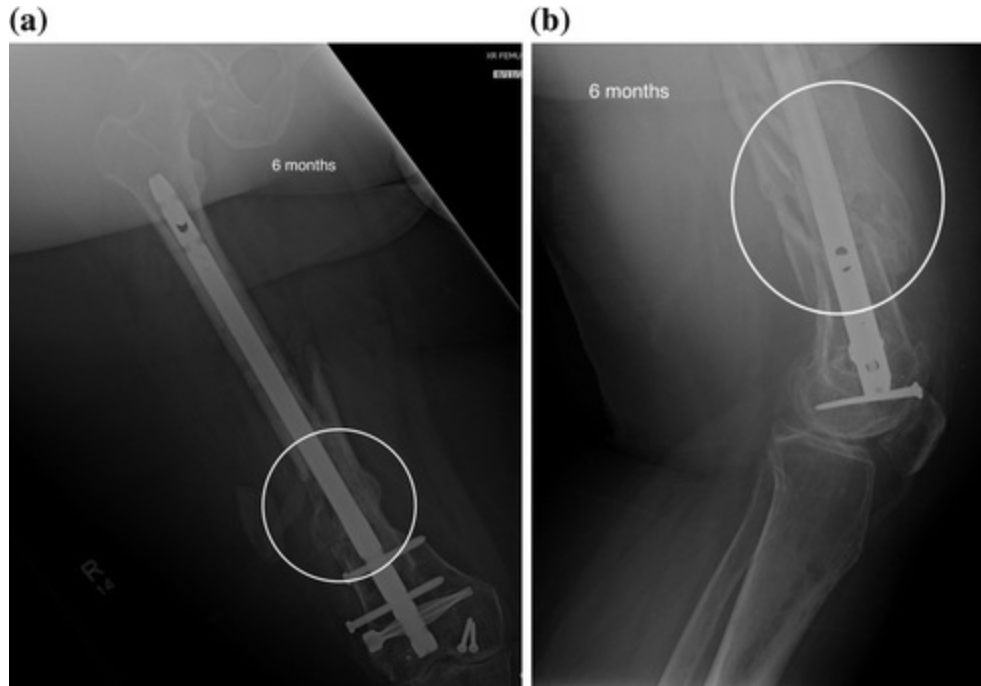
a Anteroposterior and b lateral radiographs of the right femur at 6 months showing increased consolidation and bridging of the nonunion. Abundant bone formation is visualized within the *marked areas*
